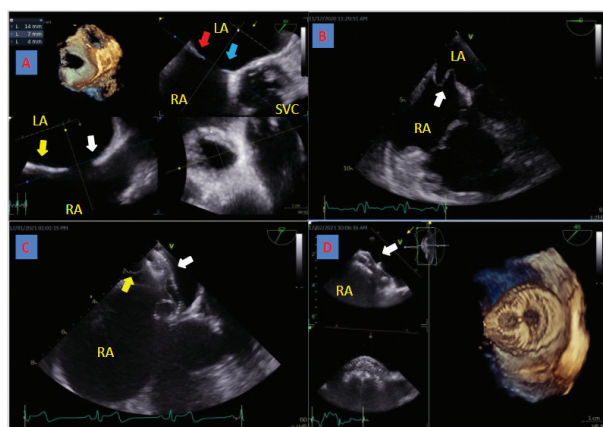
A. 3D reconstruction of interatrial septum with an atrial septal defect type II localized in the superior and anterior aspect of the septum. The postero-superior rim (superior vena cava rim) is absent (white arrow), the postero-inferior rim is 14 mm (yellow arrow), the posterior rim is 7 mm (red arrow), the antero-superior rim (aortic rim) is minimal (blue arrow — 4 mm). The shape of the ASD is elliptical with diameters of 10 and 17 mm, respectively. B. Transesophageal echocardiography, midesophageal 4-chamber view. The white arrow points to the interatrial septal aneurysm. C. The first attempt for ASD closure. Transesophageal echocardiography: a modified mid-esophageal aortic valve view during the push test. The white arrow points to the implanted occluder device, the yellow arrow points to the interatrial septal aneurysm giving poor support to the implanted device. D. The hybrid approach. The 3D reconstruction of the implanted Lifetech Cera 20-mm occluder after it was successfully secured by a single surgical suture
